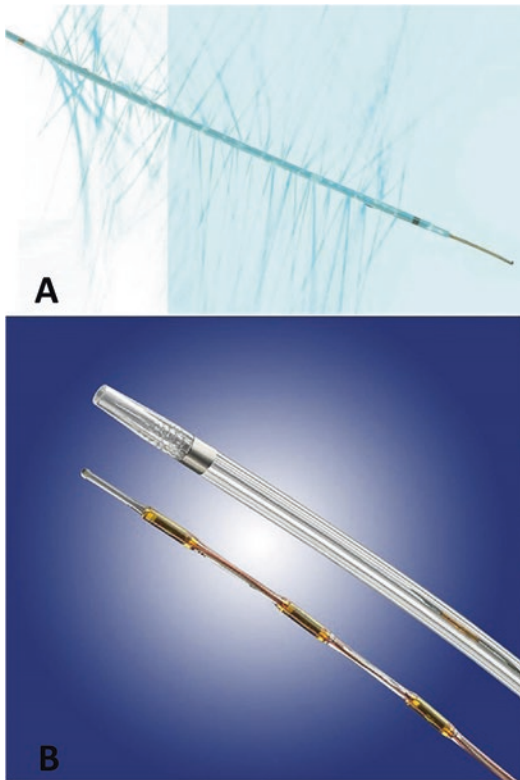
Standard and ultrasound-assisted catheter-directed thrombolysis. (a) Standard multiside hole infusion catheter. (b) EkoSonic catheter (EKOS® Corp, Bothell, Washington)
